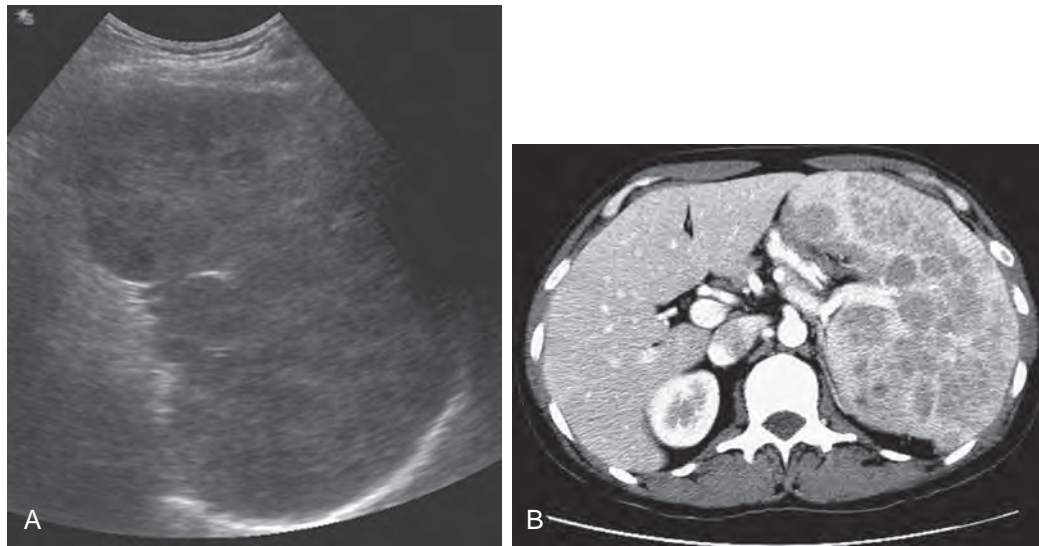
Hodgkin's lymphoma in a 42-year-old man. A. The sagittal sonogram reveals an enlarged spleen containing multiple ill-defined, hypoechoic lesions. B. The CT scan of the upper abdomen demonstrates multiple low-density masses.
